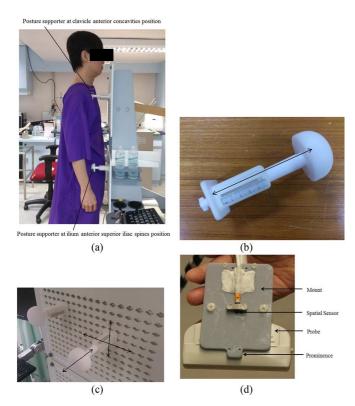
Posture supporter and spatial sensor fixation: (a) subject using body supporter during scan, (b) body supporter, (c) body supporter fixed on chest board, and (d) ultrasound probe with spatial sensor and fixation mount.
